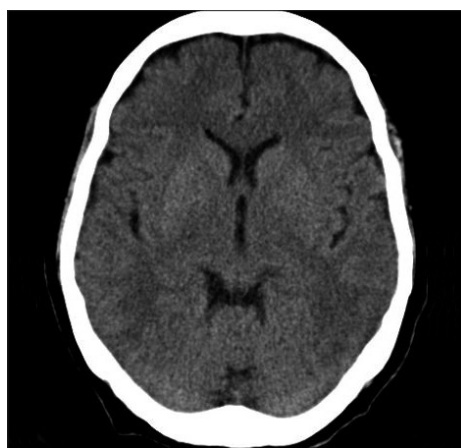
Brain computed tomography scan performed 2 weeks after initiating appropriate antibiotic therapy shows complete resolution of the pneumocephalus.
